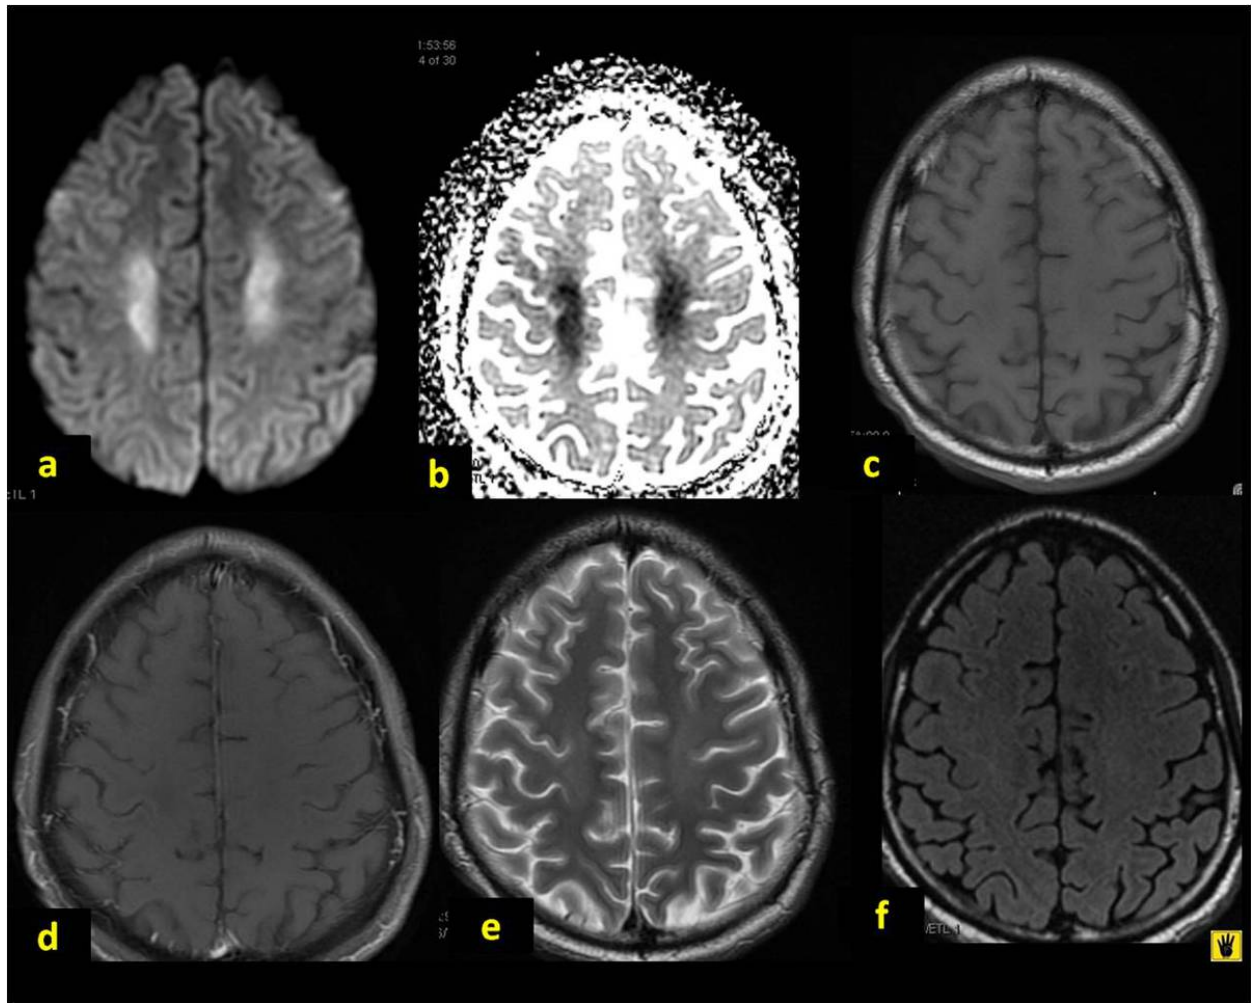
5 year old female patient with lymphoma under methotrexate therapy presented with acute right sided facial droop and slurred speech. MRI done one day after the neurological event. Bilateral symmetrical centrum semiovale areas of restricted diffusion (a) and reduced ADC value. These areas are isointense on T1WI, T2WI and FLAIR (c, e, f) with no significant enhancement (d).
